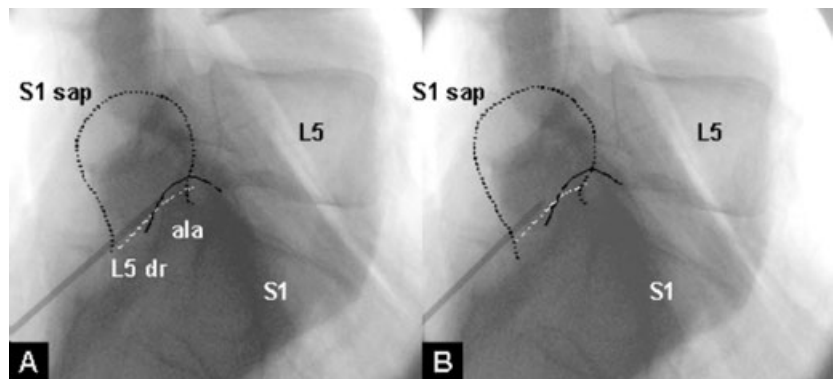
A declined radiographic view of an electrode lying parallel to, and in contact with, a right L5 dorsal ramus (dr) (c.f. Figure 8). The nerve lies in the groove between the ala of the sacrum and the root of the S1 superior articular process (sap). Abbreviation: iap = inferior articular process.
